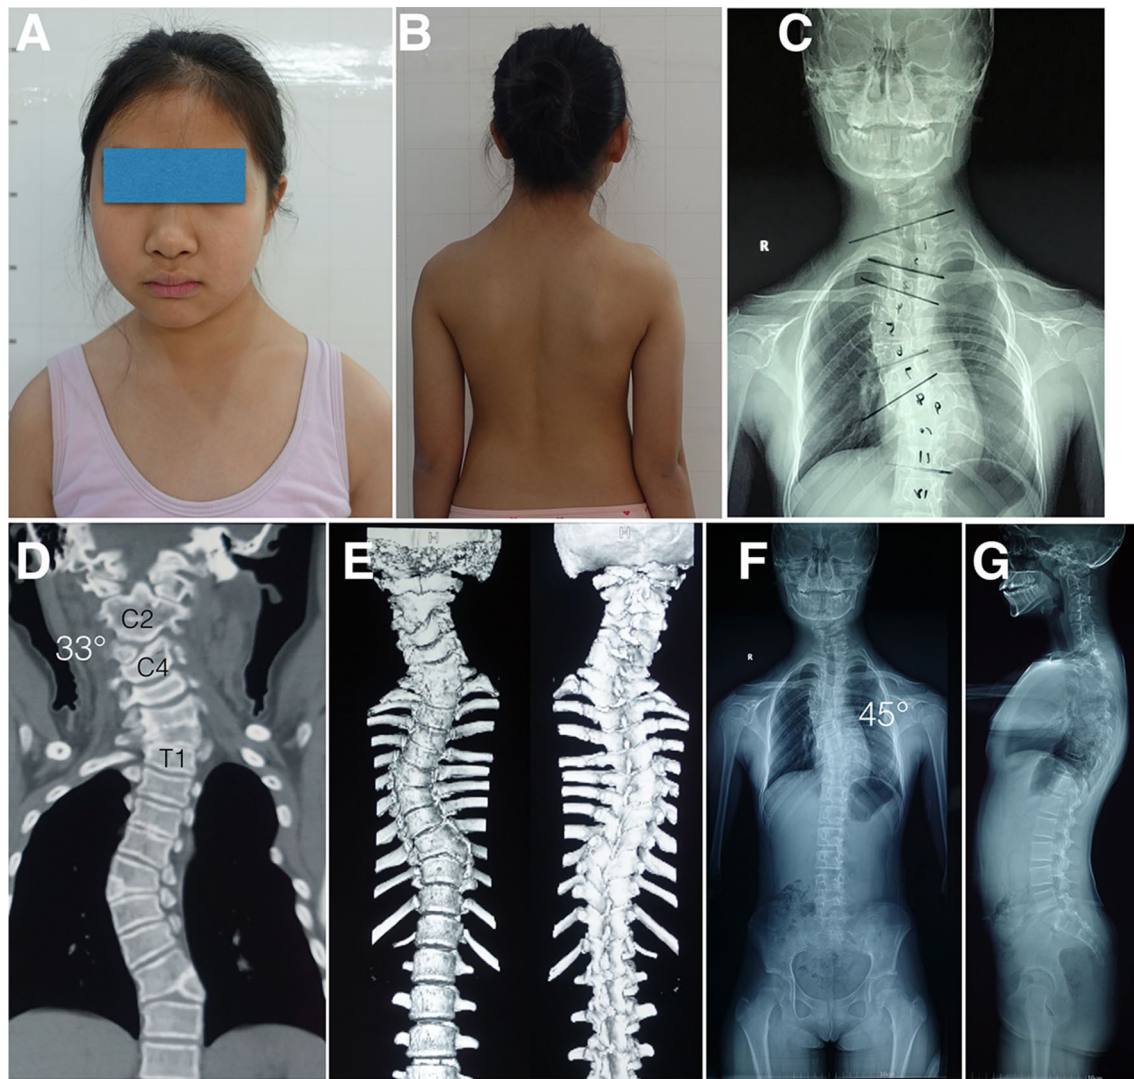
Case 2, a 12-year-old girl with C3 hemivertebra. a, b Clinical photographs. c X-ray demonstrating the C3 hemivertebra, and major cervicothoracic and thoracic curvature. d, e Computed tomographic
